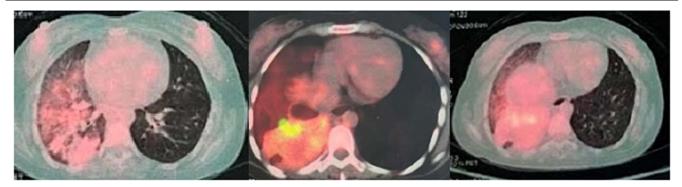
Pet-scan shows low intake in the right lung, and mild intake in right lower lobe consolidation (SUV = 4).
